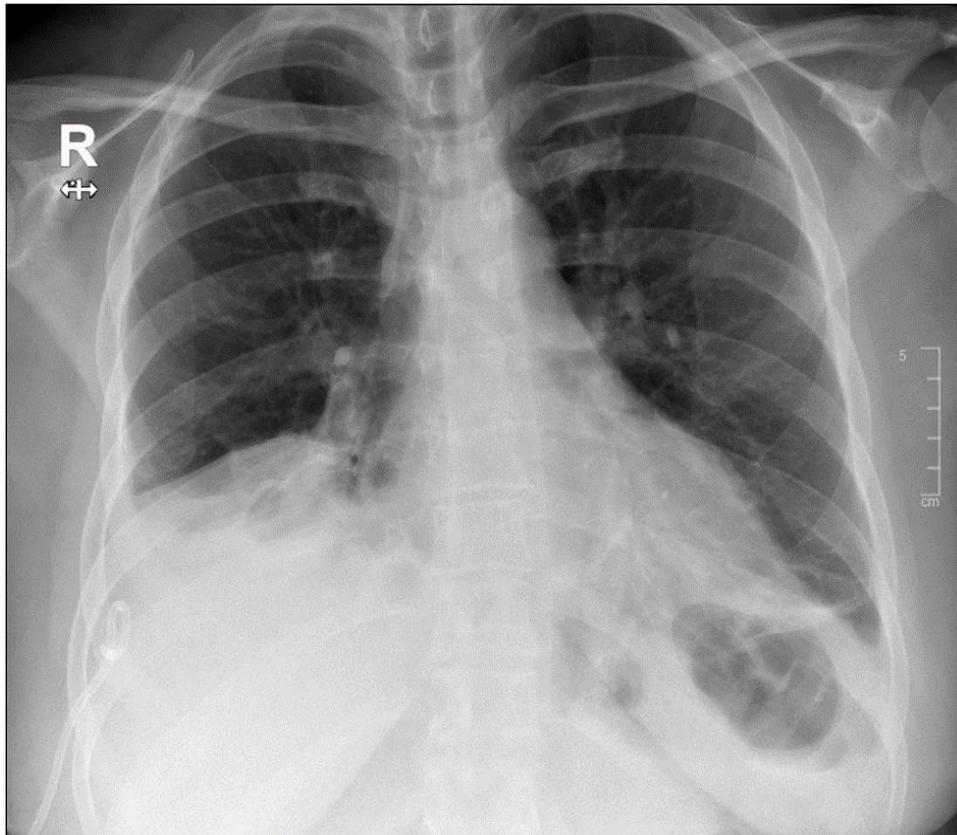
Chest radiography (x-ray) showing clear improvement of the pleural effusion post-drainage.
